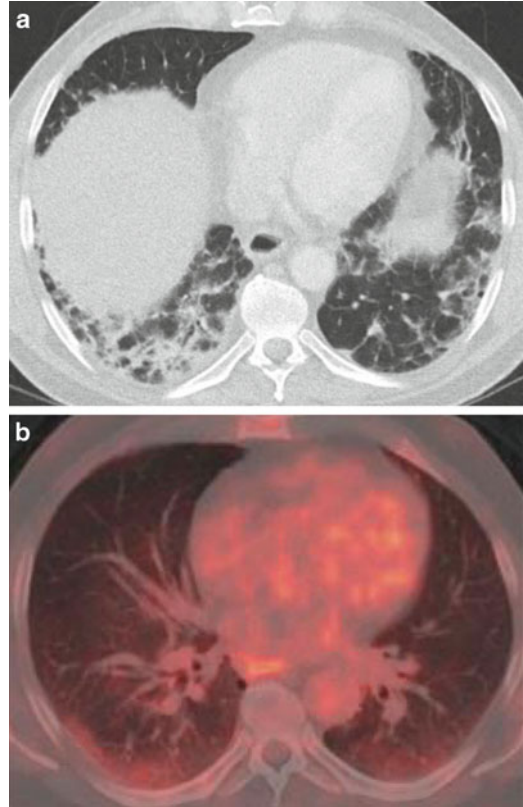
Bleomycin pulmonary toxicity. A 53-year-old man who developed severe shortness of breath 3 month after completing his fourth cycle of bleomycin. CT image (a) shows patchy ground glass with irregular septal lines and secondary pulmonary lobule sparing. Prior FDG-PET CT (b) (2 months prior to CT) showed mild uptake in the same regions. Despite supportive treatment, the patient eventually died from respiratory failure. Final pathology was in keeping with pulmonary fibrosis
